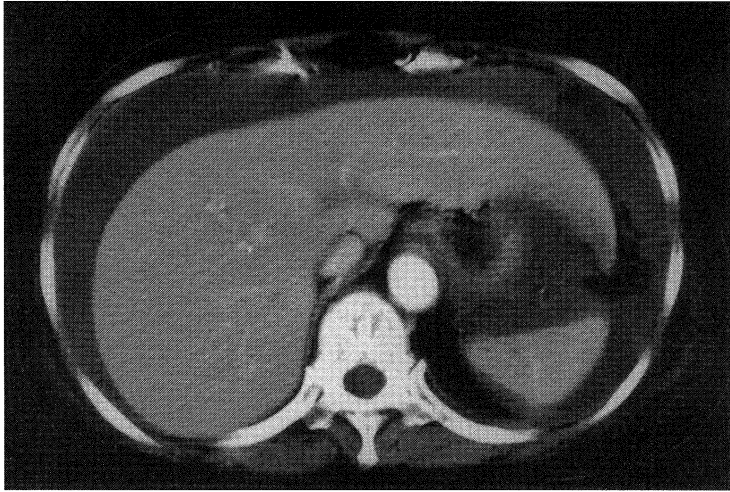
Abdominal CT shows massive intraperitoneal bleeding.
